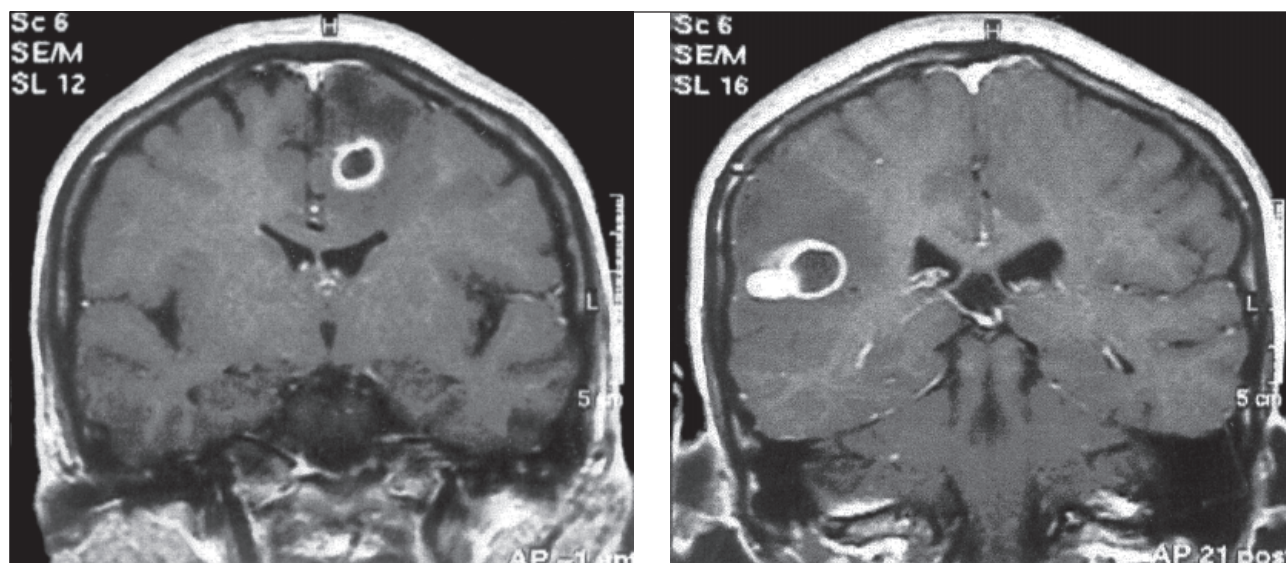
Cerebral nocardiosis: Magnetic resonance imaging of the brain of a 30-year-old woman who presented with fever and weight loss for 1 month, and generalised convulsion on the day of admission. She was found to have ulcers over the scalp and limbs from which *Nocardia asteroides* was isolated. Later she tested positive for HIV infection
